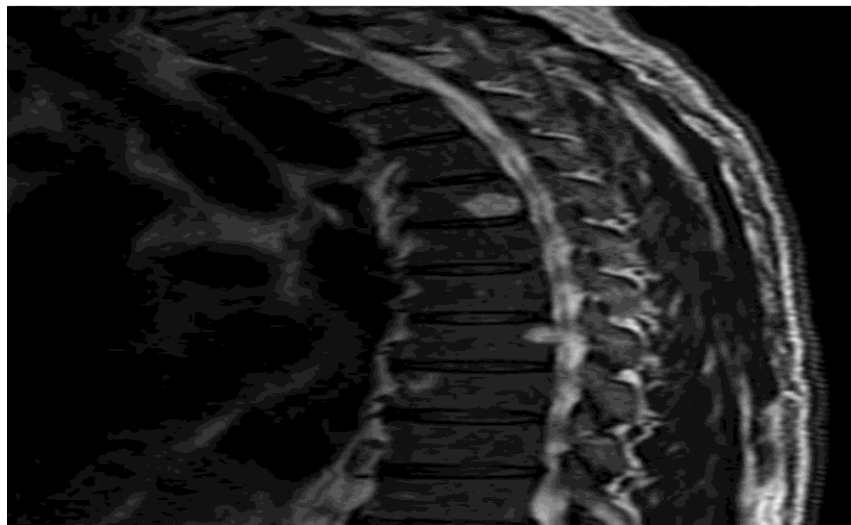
MRI breast study of 57 years old female patient with pathologically proven left breast axillary tail suspicious looking lesion. (BIRADS-6) with sagittal T2WI showed Vertebra body hemangioma.
